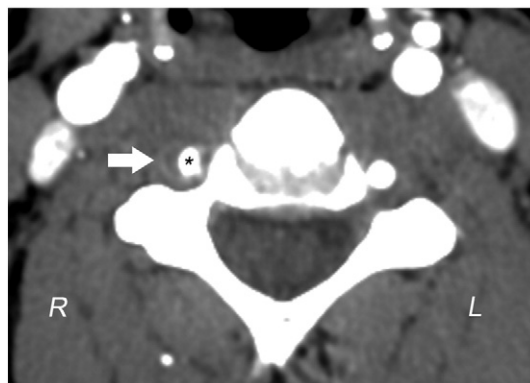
CTA with intravenous contrast at the level of C5 demonstrates a crescent-shaped mural thickening with annular enhancement (arrow) around a narrowed lumen of the right vertebral artery (asterisk).
